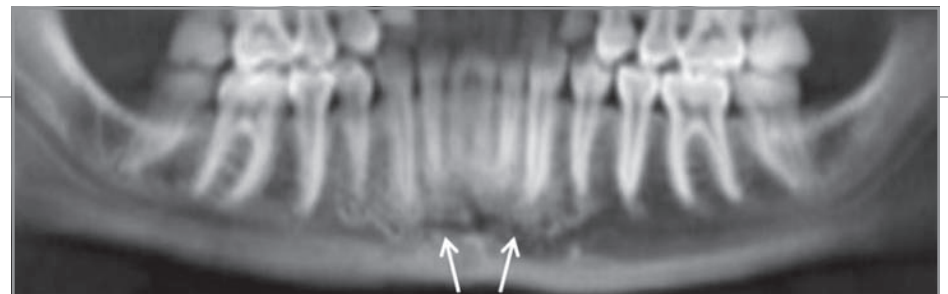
Panoramic X-ray view of incisive canal, demonstrating contralateral anastomosis.
